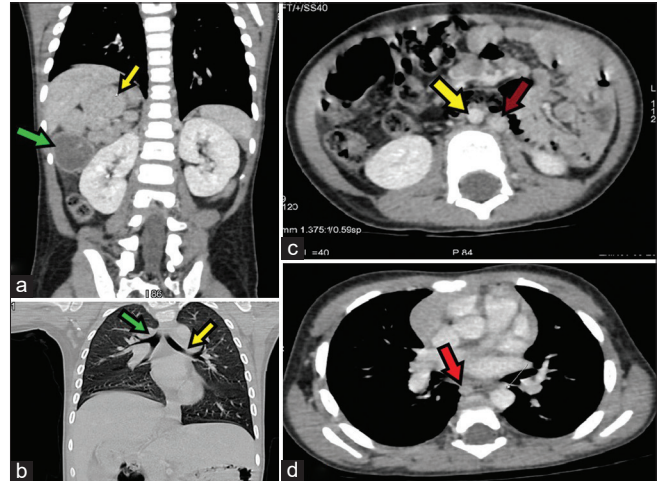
(a) Contrast-enhanced CT (CECT) of abdomen and pelvis coronal section shows multiple splenunculi (yellow arrow) in the right hypochondrium with absent parent spleen. One of the splenunculi was relatively hypodense with only marginal and peripheral enhancement, measured (4 × 3.8 × 3.7 cm) (green arrow). (b) CT lung window shows, trilobed right side lung (green arrow) and bilobed left lung (yellow arrow) with corresponding number of bronchi. (c) CECT axial section of abdomen shows aorta on the right side (yellow arrow) and inferior vena cava (IVC) (brown arrow) on the left side. (d) Contrast-enhanced CT axial section of the chest shows azygos continuation of IVC (red arrow).
